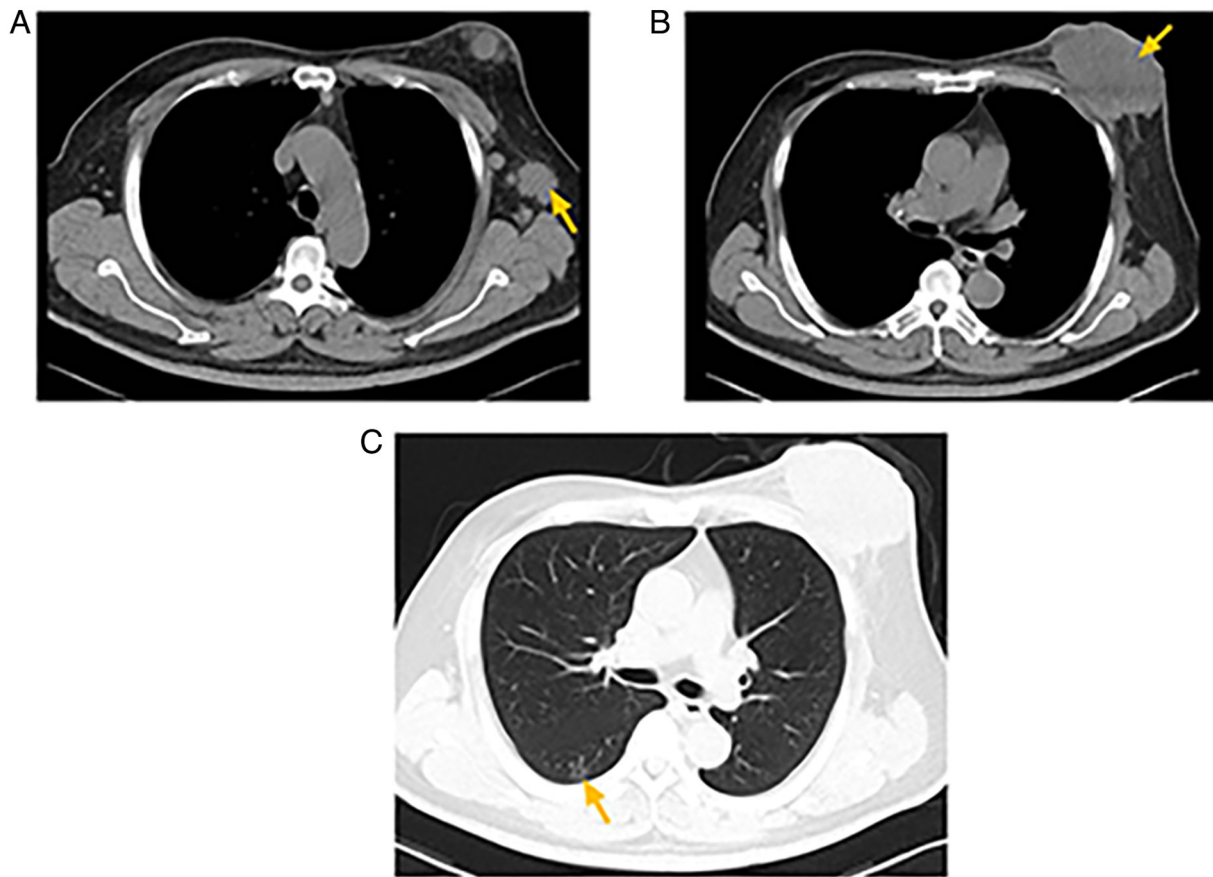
Pre-treatment CT images from June 2023. (A) CT scan showing enlarged axillary lymph nodes (yellow arrow). (B) CT scan showing the breast tumor (yellow arrow). (C) CT scan showing the lung tumor (yellow arrow). CT, computed tomography.
